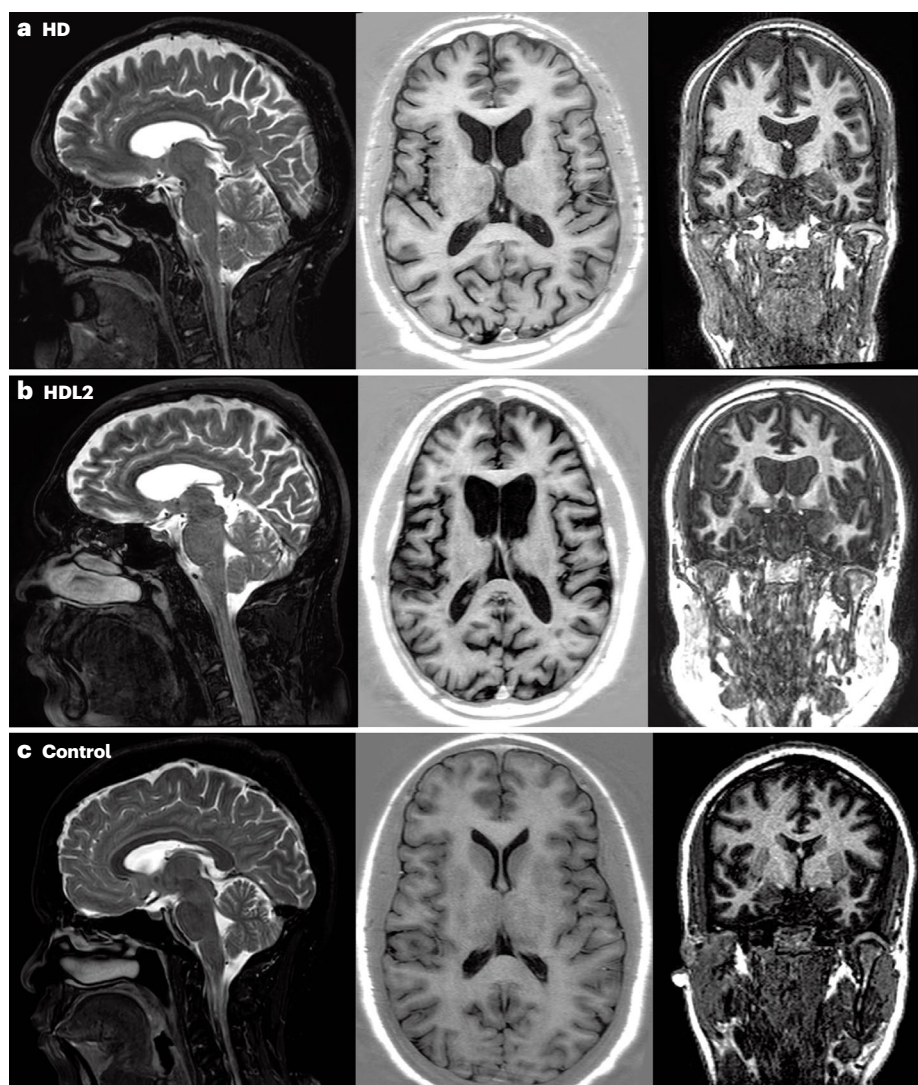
Structural MRI findings in HD and HDL2.
